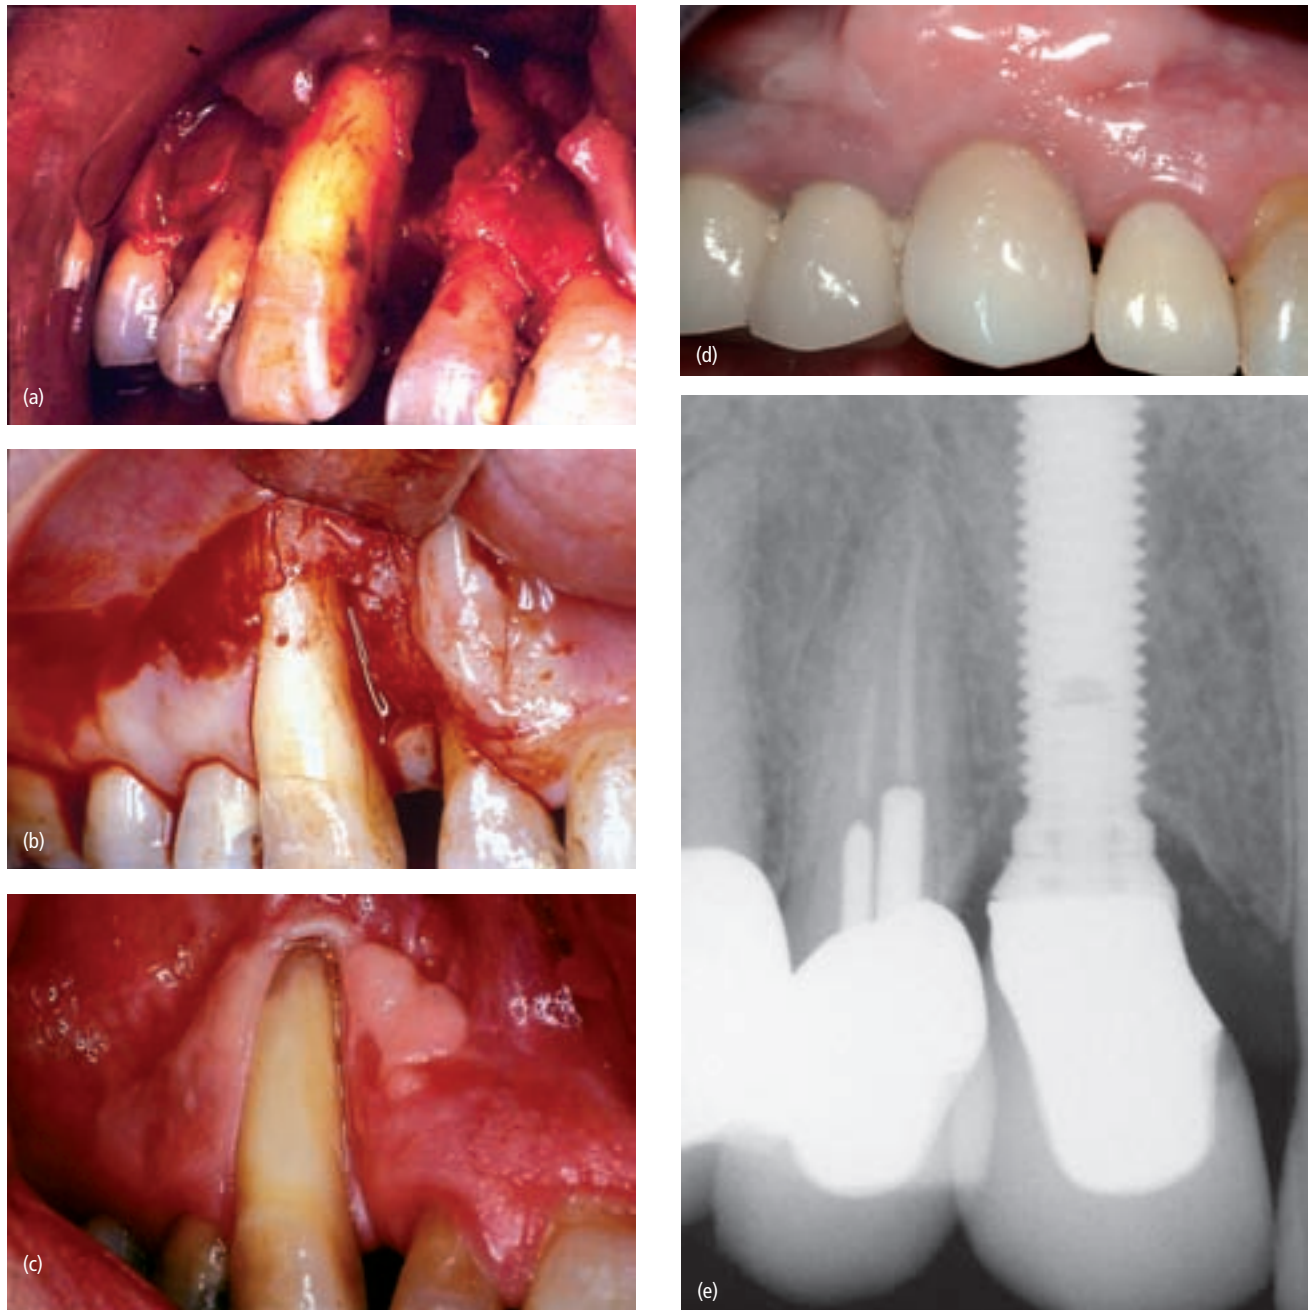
(a) A deep defect around the maxillary right cuspid wrapped around to the palatal aspect of the tooth. (b) An autogenous bone graft resulted in significant bone regeneration as seen at re-entry. (c) The labial aspect of the cuspid was significantly exposed but did not show owing to a low smile line. After 11 years the cuspid developed significant attachment loss and it was determined that the tooth was hopeless and required extraction. (d) The tooth was extracted, an implant placed, and an allograft and PG910 membrane were used in an attempt to regenerate the lost labial plate of bone. This was done at the same visit as the extraction. The implant restoration has improved the esthetics of this tooth and has been functioning for more than 4 years. (e) Radiograph taken 4 years after restoration.
